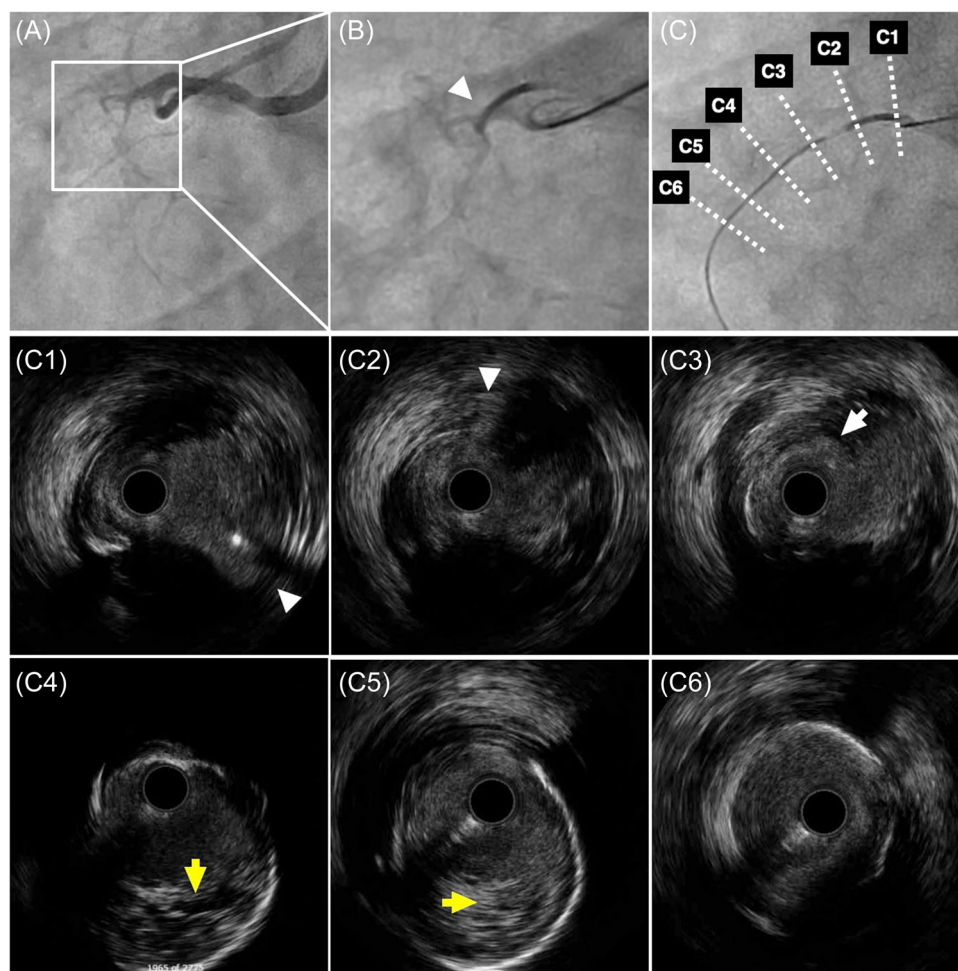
IVUS findings after HDR (from Case 2 in Figure 2). Legend: The top row shows HDR of an occluded RCA (panels A, B, and C). Following wire passage, angioplasty was performed with a 2 mm balloon to facilitate passage of an IVUS catheter. IVUS pullback images are shown from six locations: proximal RCA with branches (arrowheads, panels C1 and C2), proximal cap entry point (arrow, panel C3), intraplaque channels saturated with contrast (arrowheads, panels C4 and C5), and distal cap exit into true lumen (panel C6). Note that the IVUS catheter is intraluminal at each site. (See Videos S7 and S8 for complete recordings). HDR, HydroDynamic contrast Recanalization; IVUS, intravascular ultrasound. [Color figure can be viewed at wileyonlinelibrary.com]
